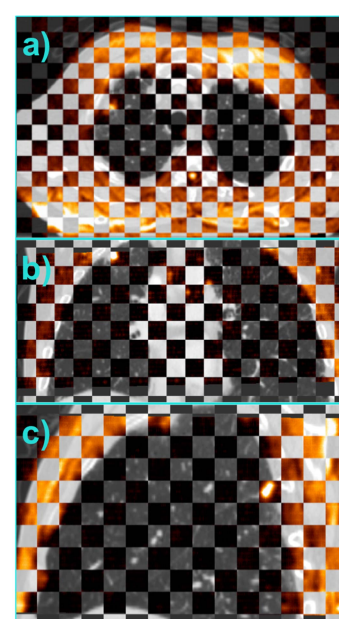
Pinnacle fusion of the DW-EPI1 (orange, day 14) and CT image (grey, day 0) of a patient with a spiculated lung mass in the right upper lobe and lymphadenopathy. a) Axial, b) coronal and c) sagittal checkerboard view.
